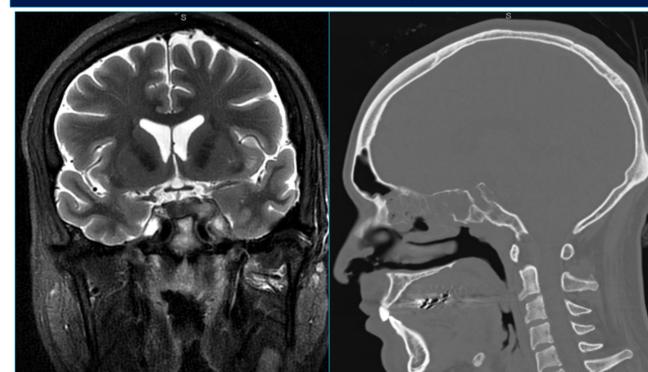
Imaging of case 2. A. Coronal T2 MRI showing hyperintense signal within the left cavernous sinus. B. Sagittal CT showing bony erosions of the sella tuberculum and clivus. Sphenoid sinus reveals complete opacification.
